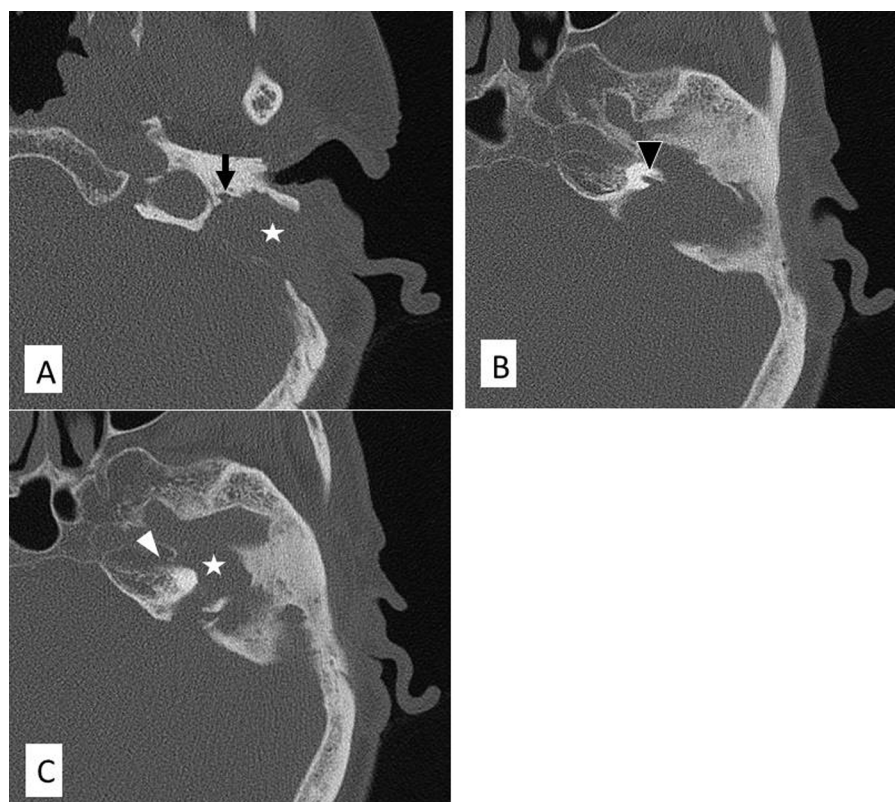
High resolution computed tomography (HRCT). (A) The left mastoid was widely exenterated, and a soft tissue density mass was exhibited (star). The facial nerve was suspected to be exposed in its mastoid segment and adhered to the mass (arrow). (B) The basal turn of the cochlea was devastated (arrowhead). (C) The soft tissue density mass (star) extended to the bone marrow at the petrous apex (white arrowhead).
